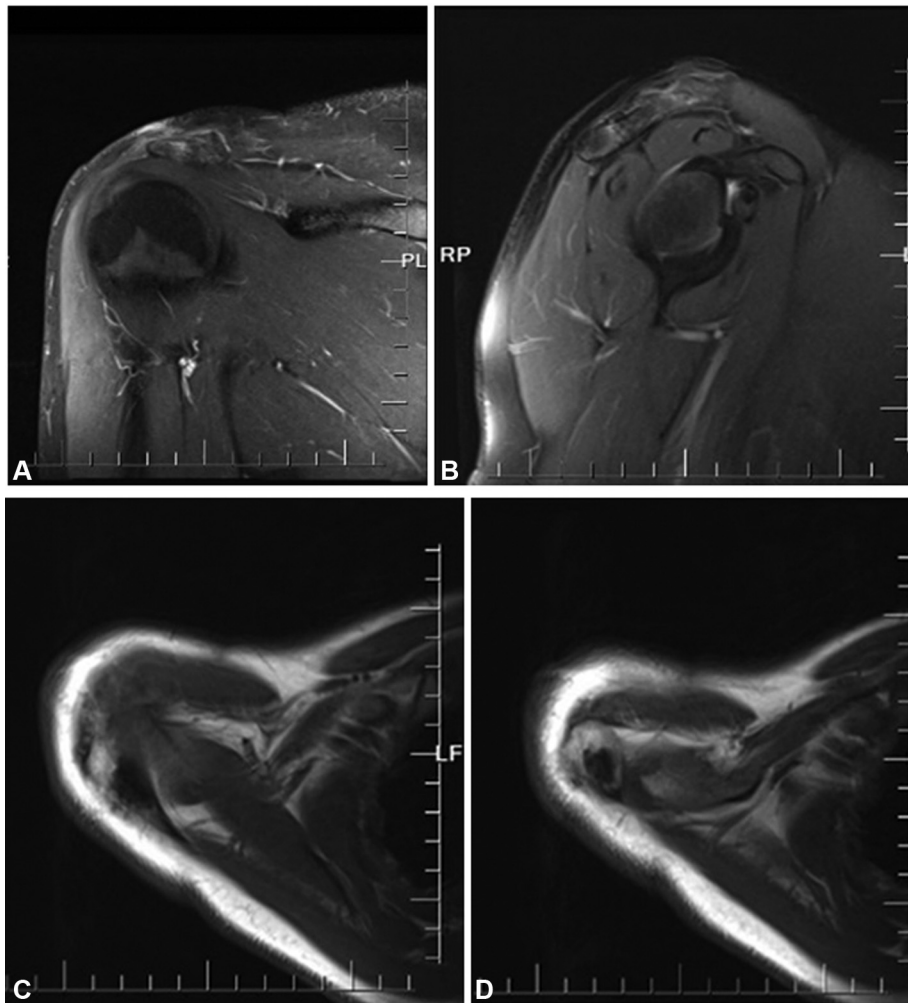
(A-D) Magnetic resonance imaging scans of the 6th postoperative month: axial T1-weighted images showing an area with partial absence of a heterogenous hypointense signal related to the postoperative changes in the acromion. Coronal and sagittal lipid-suppressed T2-weighted images showing the postoperative granulation tissue, sclerosis, and a heterogenous hyperintense image with rough contour, secondary to the surgical graft material.
